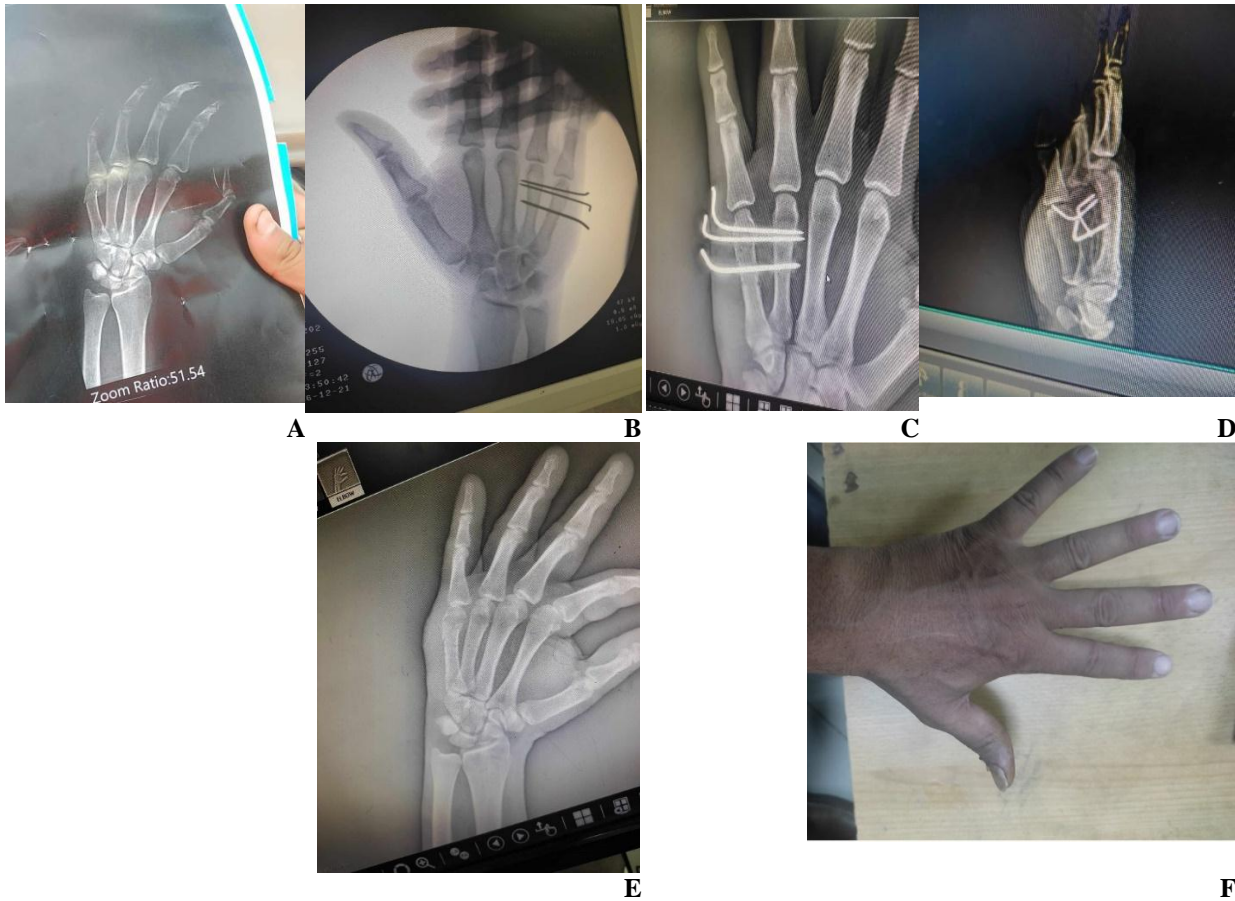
(A) Initial X ray before treatment, (B) Intra-operative x-ray, (C) Follow up 2 weeks after fixation, (D) 4 weeks post-operative x-rays, (E) 6 weeks postoperative x-rays, (F) 8 weeks postoperative
